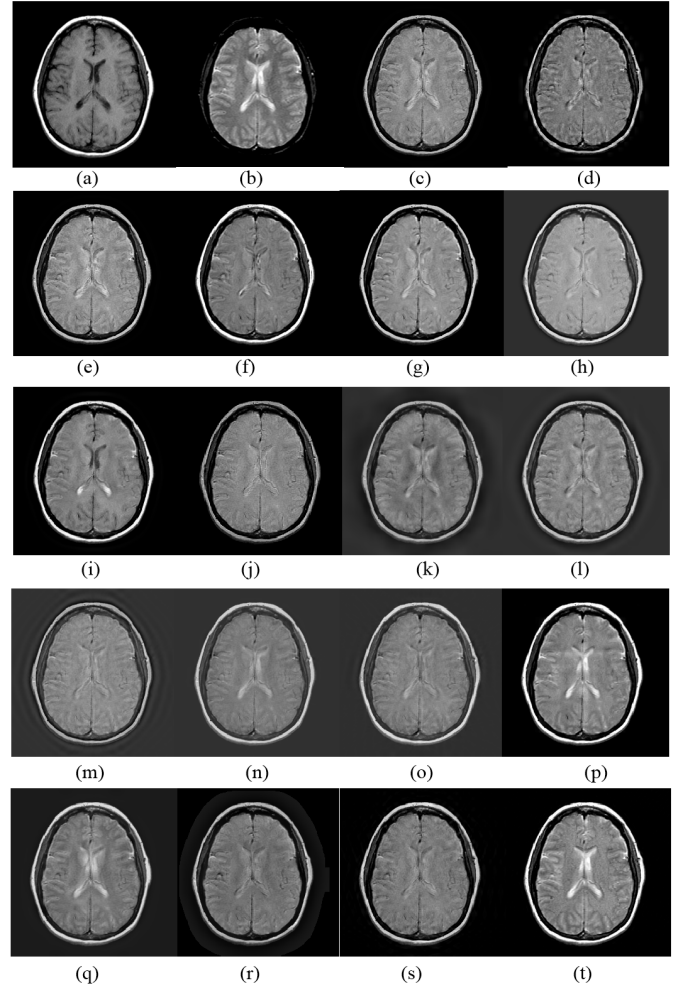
Experiments for S1. (a) CT. (b) MRI. (c) GP [52]. (d) DWT [52], [53]. (e) fsdP [52]. (f) GFS [54]. (g) CSR [55]. (h) ASR [56]. (i) GFF [57]. (j) MSVD [58]. (k) DTDWT [59]. (l) SWT [60] [61]. (m) CVT [62]. (n) DTCWT-SR [63]. (o) CVT-SR [63]. (p) LRS DL [64]. (q) PCLLE [65]. (r) MSGIF [66]. (s) DCHWT [67]. (t) Proposed.
